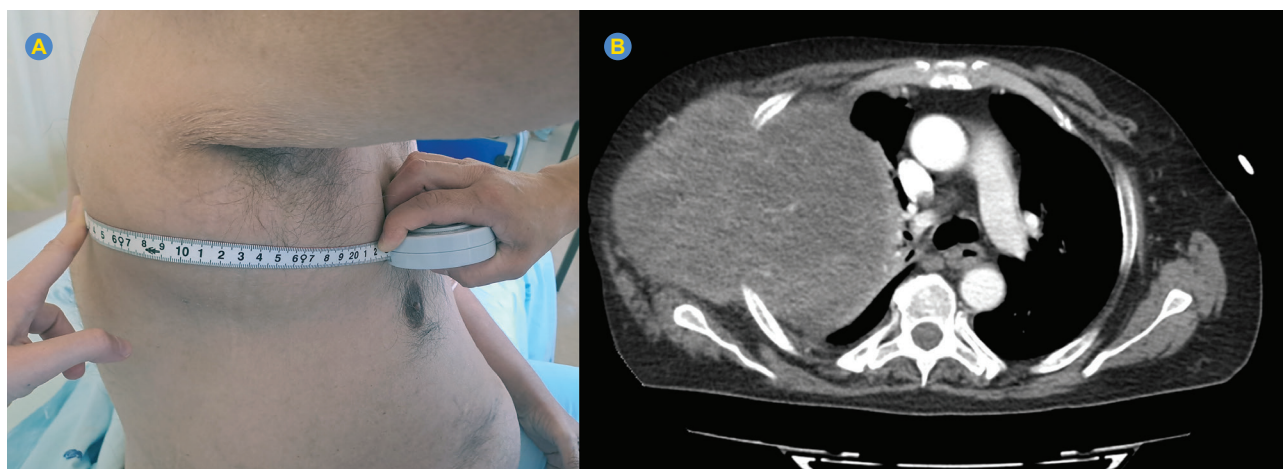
Physical examination: large, indurated mass in the right thoracic wall, adherent to deep tissue planes (A). Thoracoabdominal CT scan: a large mass of soft tissues, 18 cm in size, heterogeneous, with intra and extra-thoracic components, causing destruction of rib arches and right lung collapse (B).
